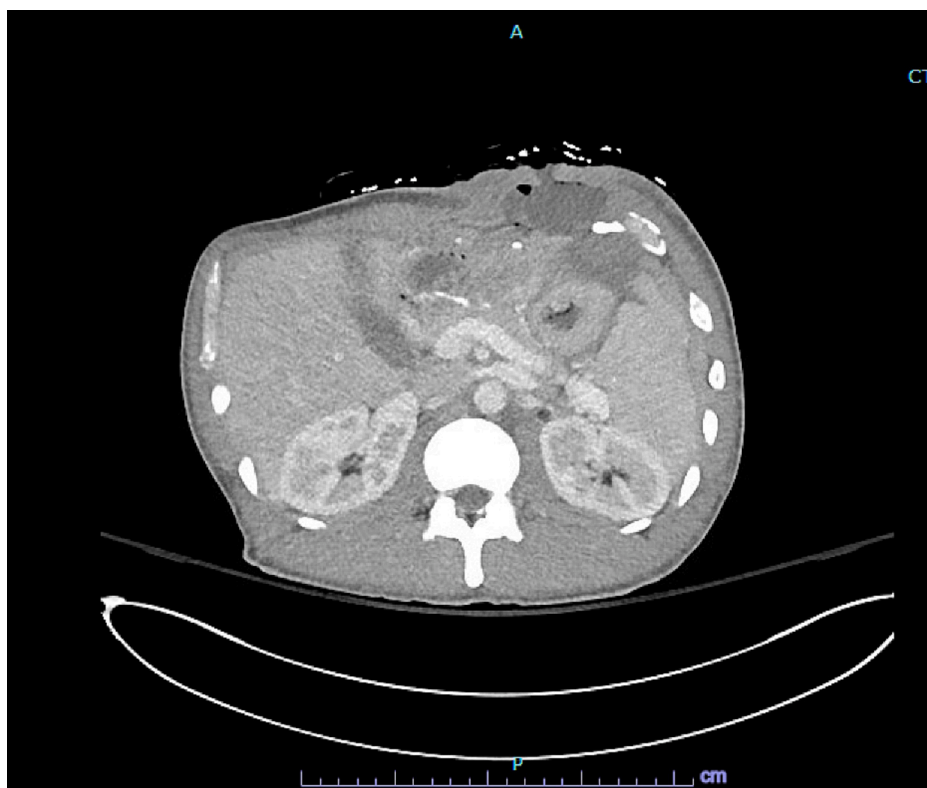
CT scan GC fistula.
